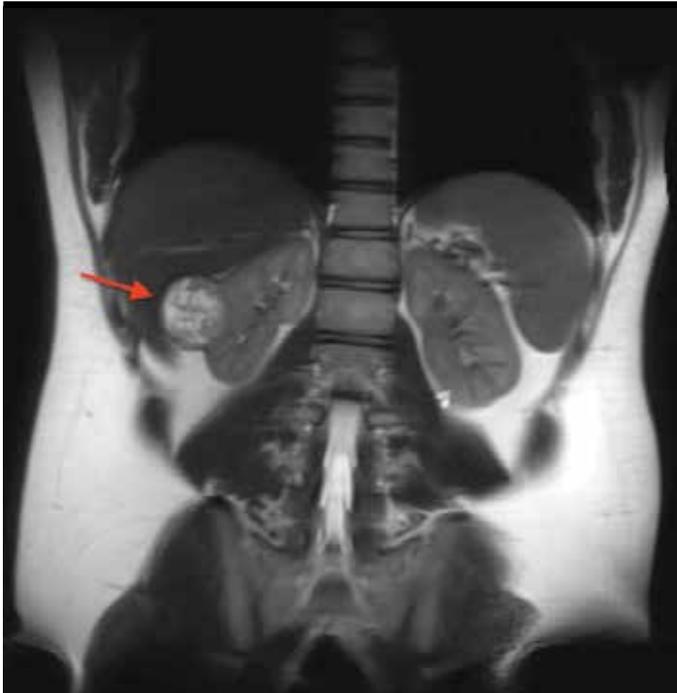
Contrast-enhanced MRI of the patient prior to surgery
